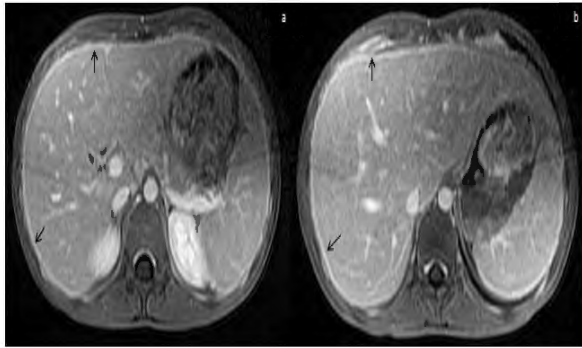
On enhanced axial T1-weighted series (a,b), smooth and uninterrupted, specific thickening and enhancement was noticed on peritoneal surfaces (black arrows).
